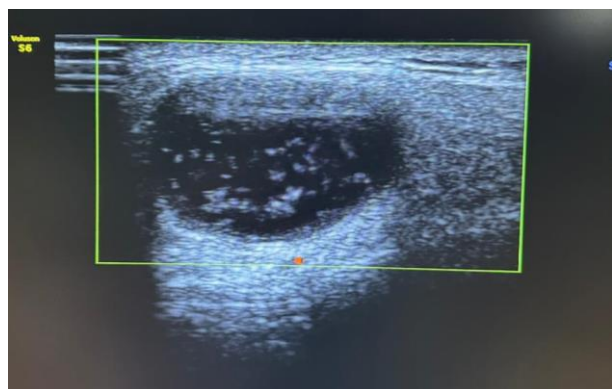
Ultrasonography suggestive of lymphoepithelial cyst
